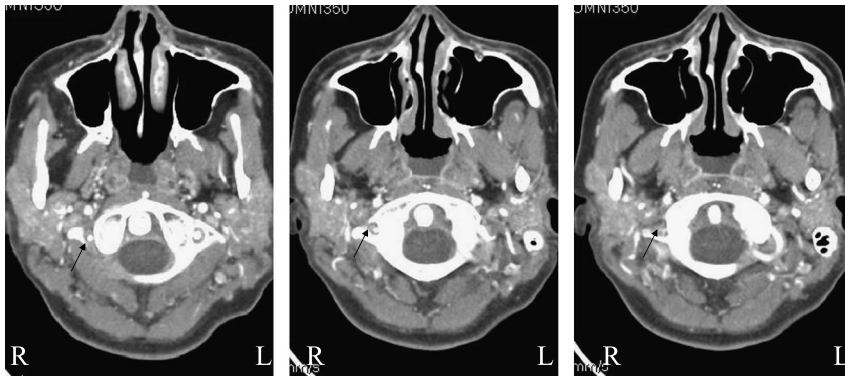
Radiographic findings. Computed tomography scan of the base of the skull and upper cervical vertebrae. Serial sections of computer tomography scan with contrast at the upper cervical levels indicate an irregular and poorly visualized right vertebral artery from transverse foramen of C1 to the origin of basilar artery, raising the possibility of dissection.
